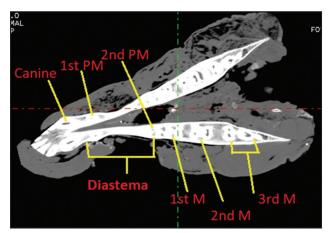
Multiplanar CT images in dorsal plane demonstrated arrangement of teeth in horizontal ramus with diastema.
